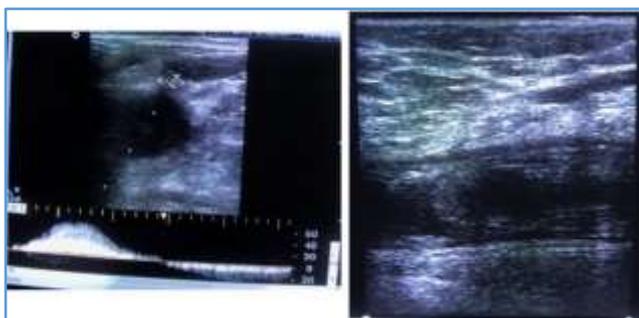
Colour Doppler Image showing Normal SFA, SFV, Profunda Femoris Vein
